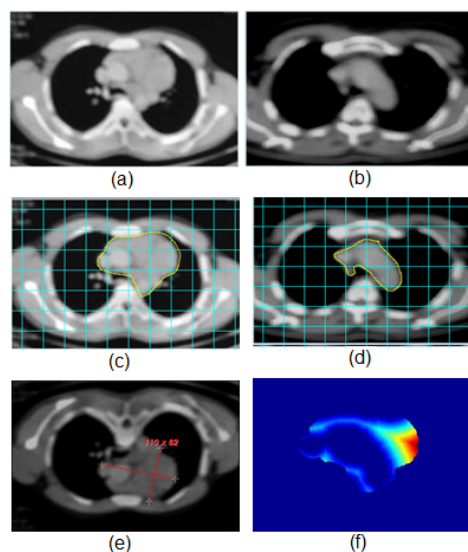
Novel approach to volume calculation using the local dissimilarity volume. Two MRI medical images: (a–d) MRI Images after segmentation; (e) Classical approach for volume calculation; (f) Local dissimilarity map between (c,d).
